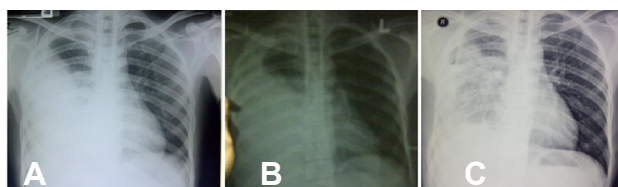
The chest X-ray before thoracosentesis (A), after the 1st thoracosentesis, 900 ml volume pleural drainage (B), and after 2nd thoracosentesis, 800 ml pleural drainage (C) .
